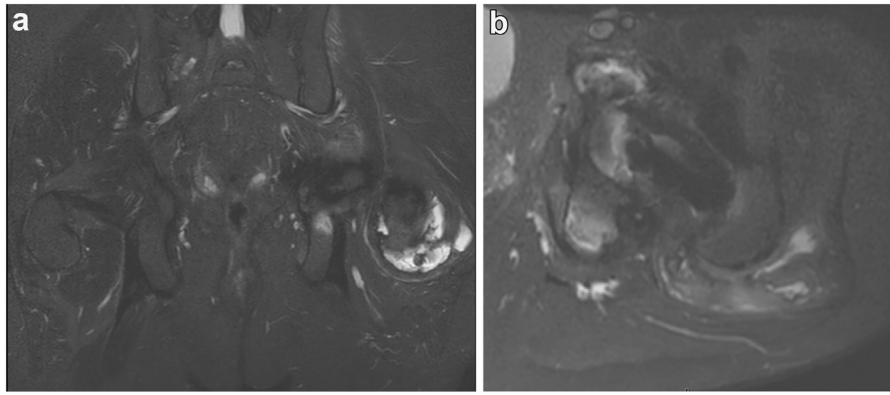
Magnetic resonance imaging (MRI) images with (a) coronal and (b) axial cuts demonstrating focal T2 hyperintense signal about the hip capsule that decompresses posteriorly to a $7.8 \times 6.5 \times 8.5$ cm heterogeneous fluid collection posteriorly along the gluteus maximus musculature.
